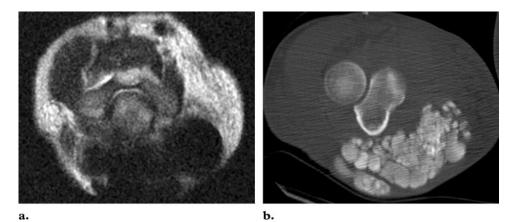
MR imaging appearance of tumoral calcinosis. (a) Axial T1-weighted MR image shows tumoral calcinosis at the extensor surface of the elbow. The tumoral calcinosis appears as multiple rounded masses with low signal intensity. (b) Correlative CT scan shows the distribution and morphology of the lesions.
